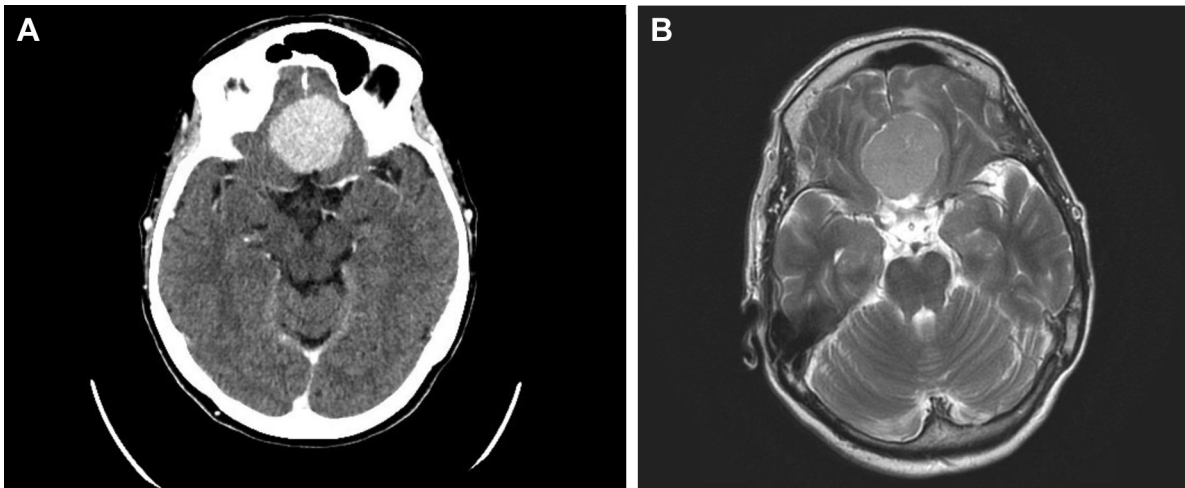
(A) Computed tomography and (B) magnetic resonance imaging head: broad-based dural mass measuring 34 × 35 × 27 mm centred in the anterior cranial fossa.
